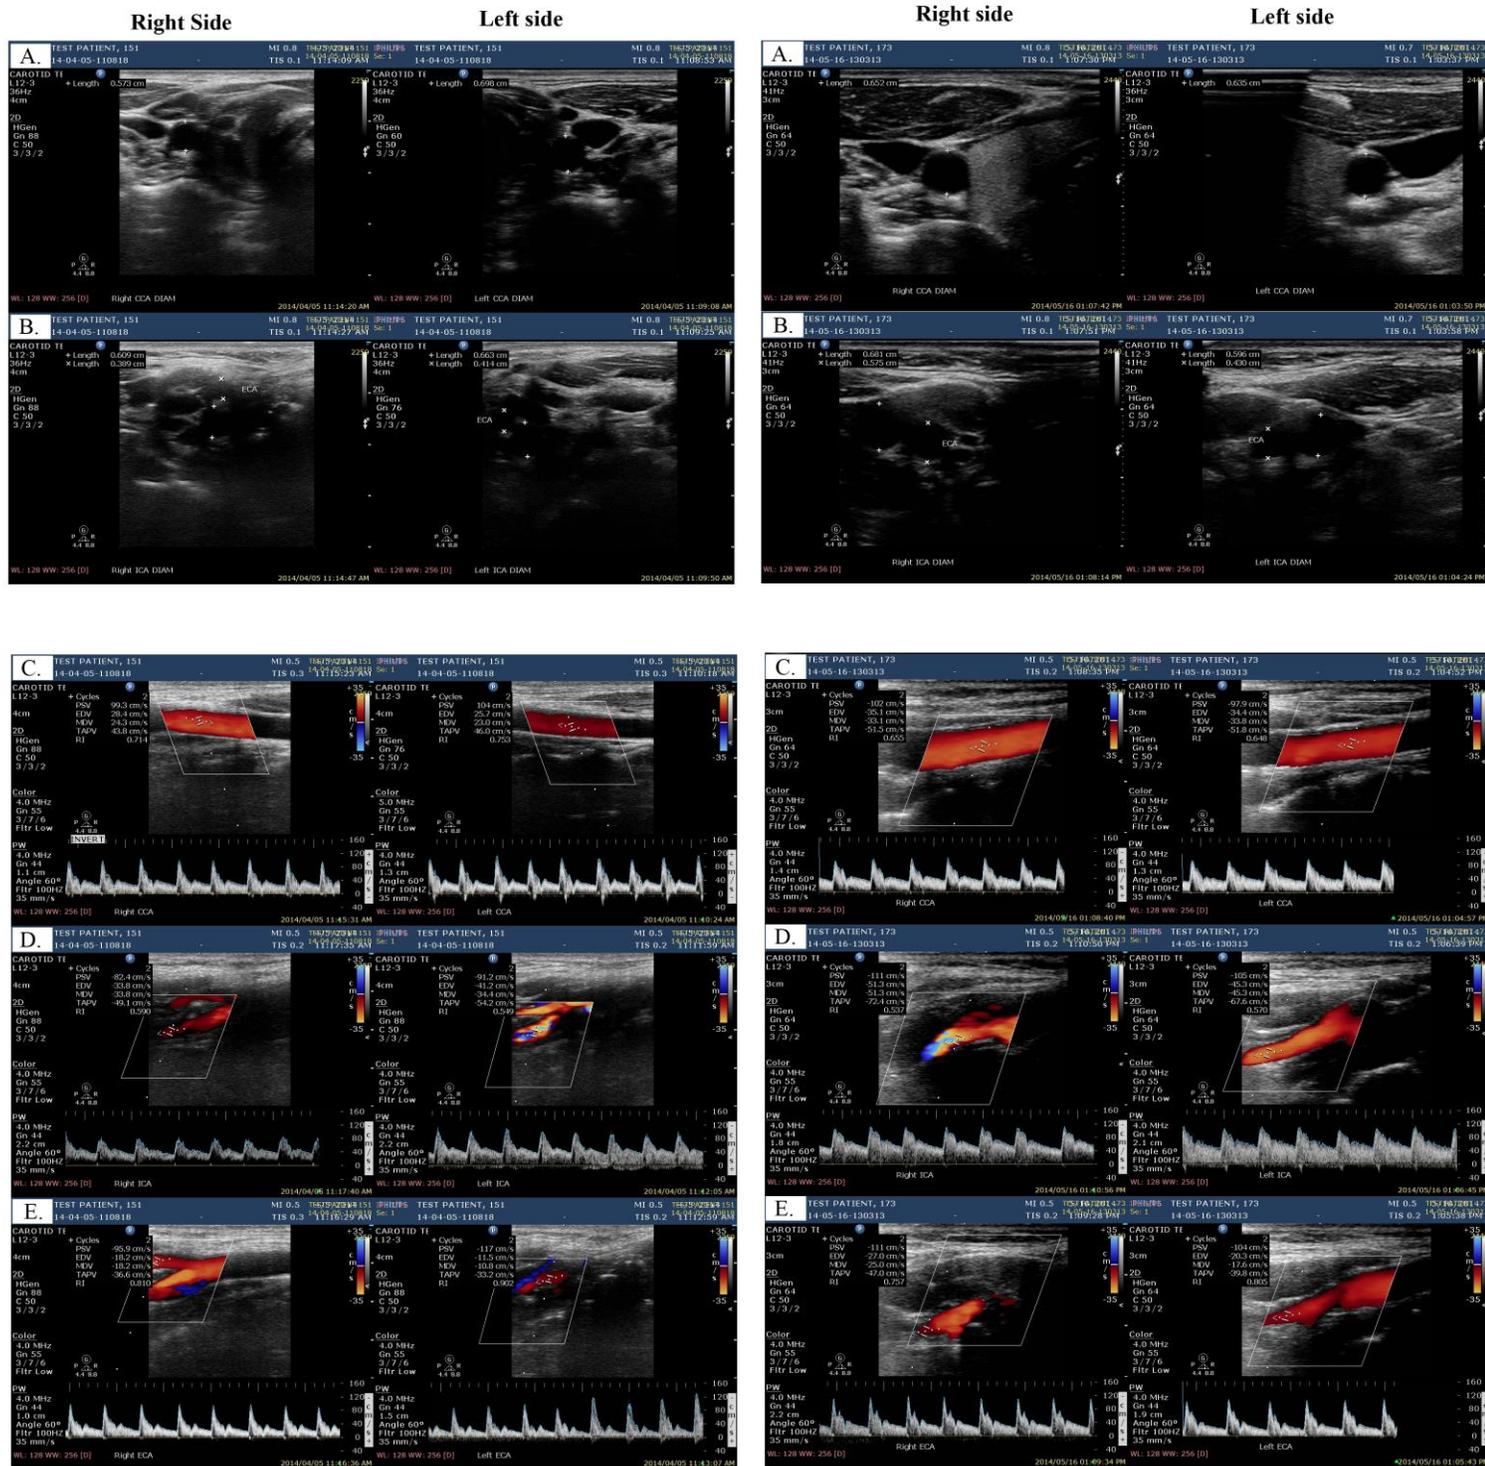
Doppler ultrasound B-mode images showing diameters of the CCAs (A), ICAs and ECAs (B); and Colour and Spectral Doppler ultrasound imaging of the CCAs (C), ICAs (D) and ECAs (E) of a right- and left-handed subject.
